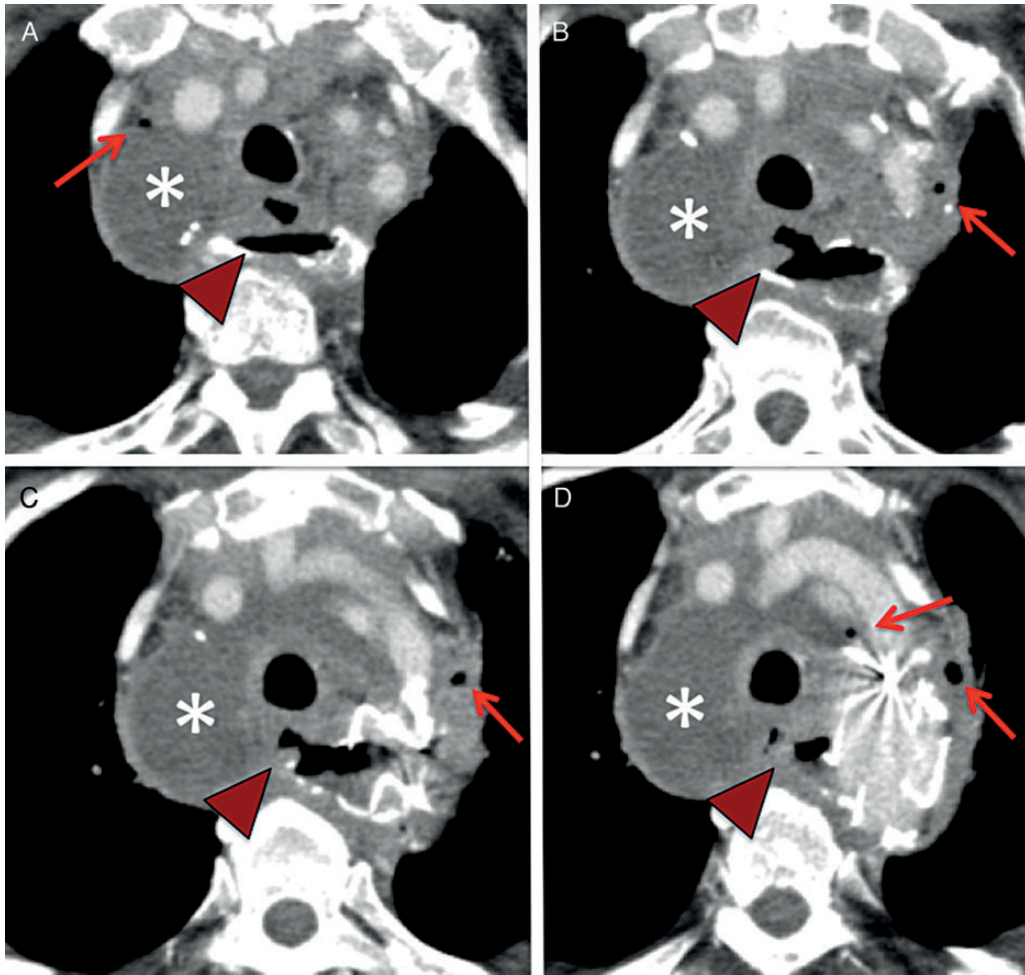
Computed tomography after readmission showing mediastinitis (asterisk) and an aorto-oesophageal fistula (dark red arrow heads) after TEVAR at the level of the transverse arch (A–D). Ectopic gas can be found within the mediastinum (red arrows).
